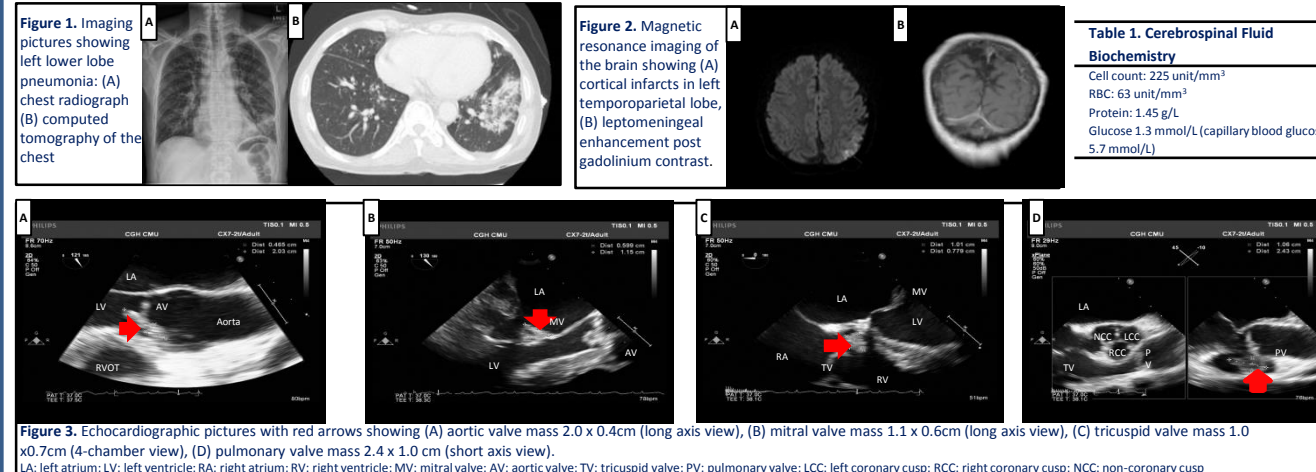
Imaging pictures showing left lower lobe pneumonia: (A) chest radiograph (B) computed tomography of the chest
